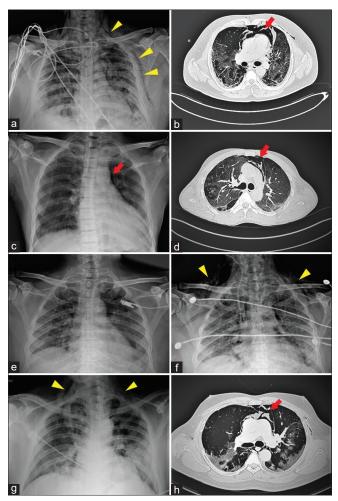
Radiological images. (a) Diffuse b/l infiltrates with SCE on CXR; (b) Diffuse GGO with mosaic attenuation and SPM on chest CT; (c) Air density along medial aspect of left lung on CXR; (d) Diffuse patchy GGO with mosaic attenuation, thickened vessels in right hilar region along with SPM on chest CT; (e) Patchy b/l infiltrates on CXR; (f) Diffuse b/l infiltrates with SCE on CXR; (g) B/l hilar and lower zone infiltrates with SCE on CXR; H. B/l dependent distribution of GGO and SPM on chest CT (a, b-case 1; c and d-case 2; e and f-case 3; g and h-case 4; Yellow arrow heads-SCE; Red arrows- SPM)
